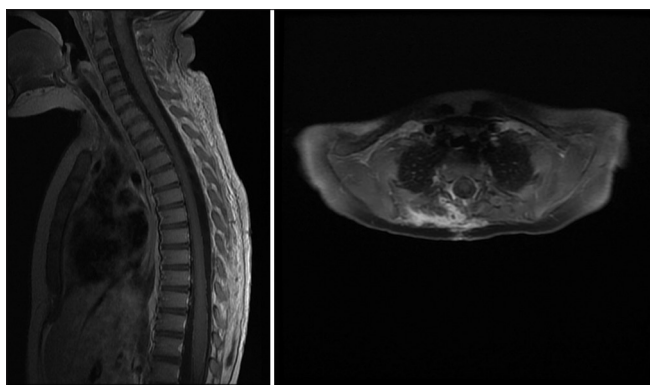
Postoperative holo-spine T1-weighted magnetic resonance imaging sequences showing a complete spontaneous spinal epidural hematomas removal and decompression of the spinal cord.
